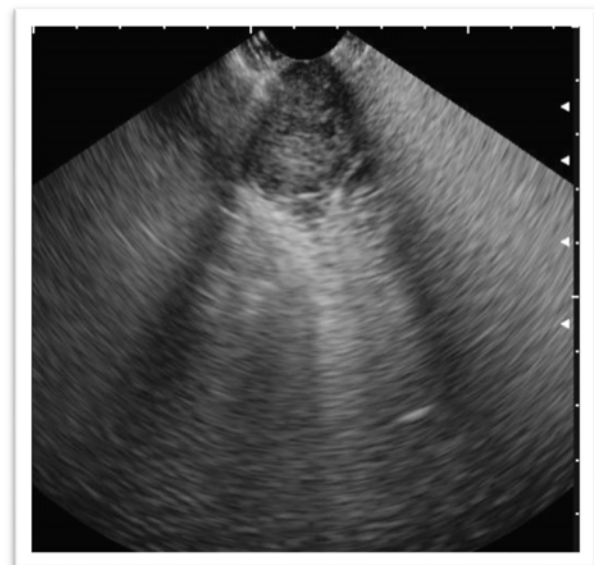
Showing ultrasound
